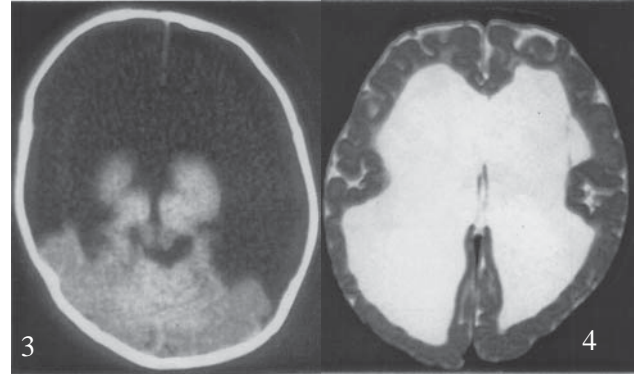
Axial CT image shows a classical case of hydranencephaly with relative sparing of thalami and cerebellum.
